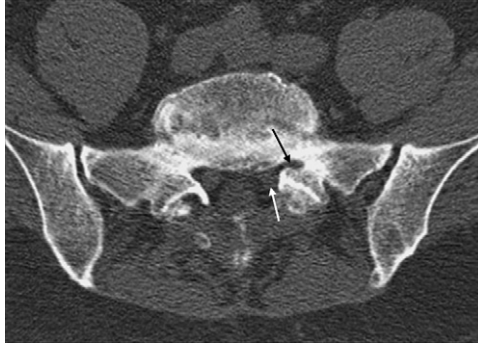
Lateral recess stenosis: axial CT—left S1 lateral stenosis (*dark arrow*) resulting from facet joint hypertrophy; note the left S1 nerve is pushed medially (*white arrow*). The patient was asymptomatic.
